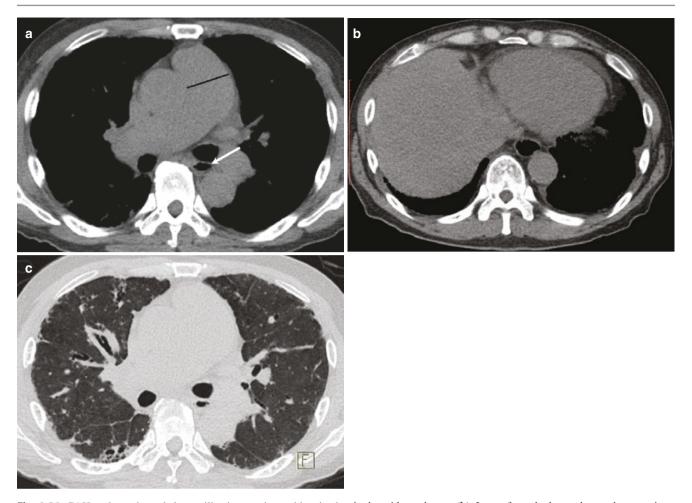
PAH and esophageal dysmotility in a patient with mixed connective tissue disease. (a) Axial unenhanced CT shows dilated main pulmonary artery with respect to ascending aorta with an air-fluid level
